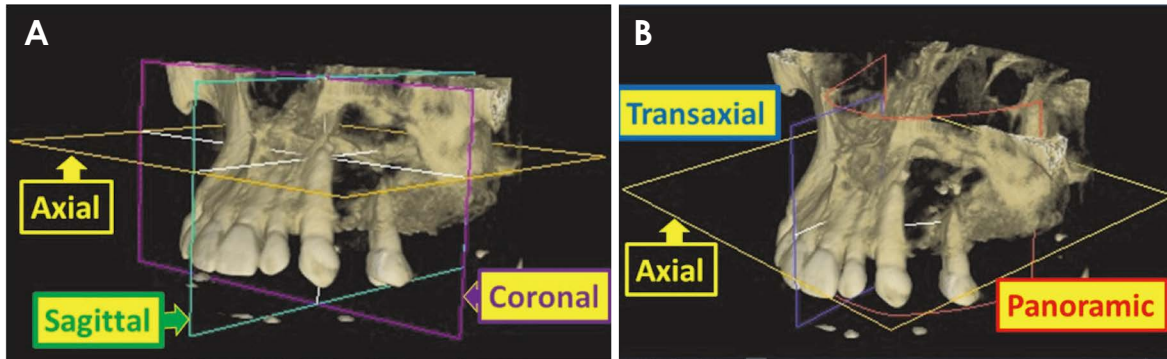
An 8 cm × 8 cm field-of-view of cone-beam computed tomography of a lesion (not found in this study). A. The orthogonal MPR displays the axial (yellow), coronal (purple) and sagittal (green) planes. B. The panoramic plane (red) is constructed by the operator from the axial plane (yellow). The trans-axial plane (blue) is automatically produced perpendicularly from the panoramic plane. MPR: multiplanar reconstruction.
